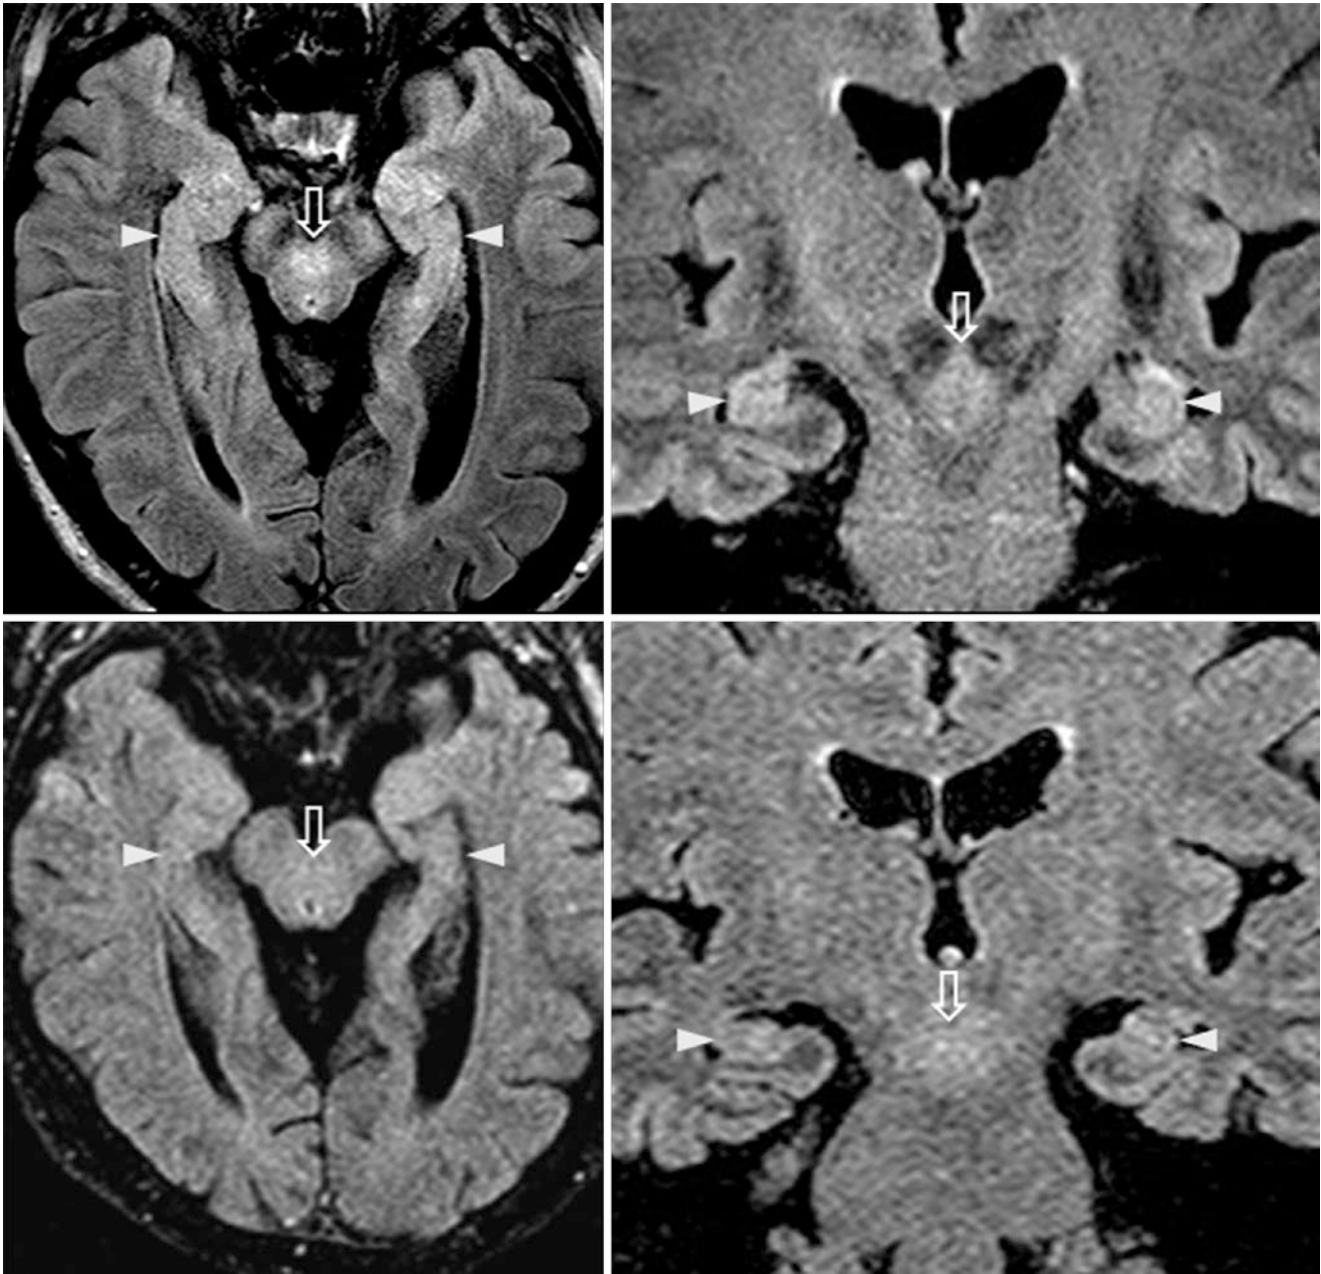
A 63-year-old had a 3 T MRI with bright hippocampi (arrowheads) on axial (top left) and coronal (top right) FLAIR. Such hyperintensity mimics herpetic encephalitis, limbic encephalitis, or seizure sequelae. The DSCPs (open arrows) are also bright. Two years
